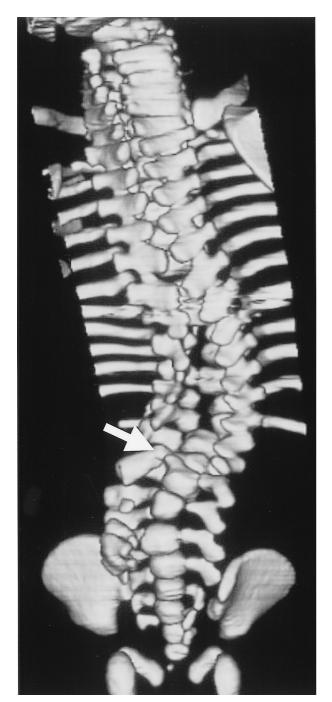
Spinal 3 Dimmensional CT image demonstrated an osseous spur on the L3 vertebral column(arrow)coexisting with hemi vertebrae at Th11, 12.
